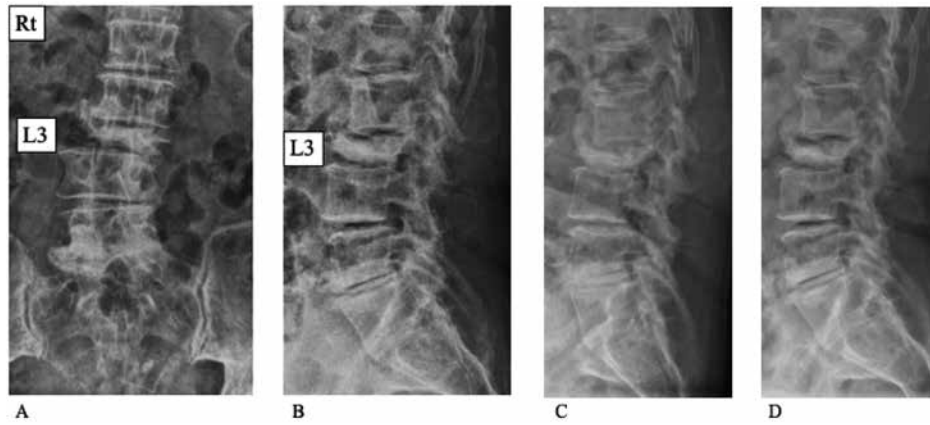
Preoperative plain radiographs of the lumbar spine. A : Scoliotic change due to the collapsed L3 vertebra and lumbar spondylosis. B : L3 vertebral fracture (the height of vertebral body collapsed by less than 50%) and local kyphotic change at the L2-L3 intervertebral disc level. C : Lateral view in flexion (anterior flexion). D : Lateral view in extension (posterior flexion).
